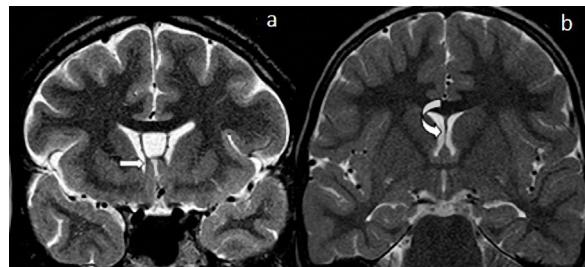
a. Coronal T2 weighted MRI image in a 41 year old patient with incidental persistence of the cavum septum pellucidum showing the left and right septal leaflets associated with the fornices (block arrow). b. Coronal T2 weighted MRI image in a 2 year old patient with normal midline septum pellucidum (curved arrow), which is made up of the fused septal leaflets.
